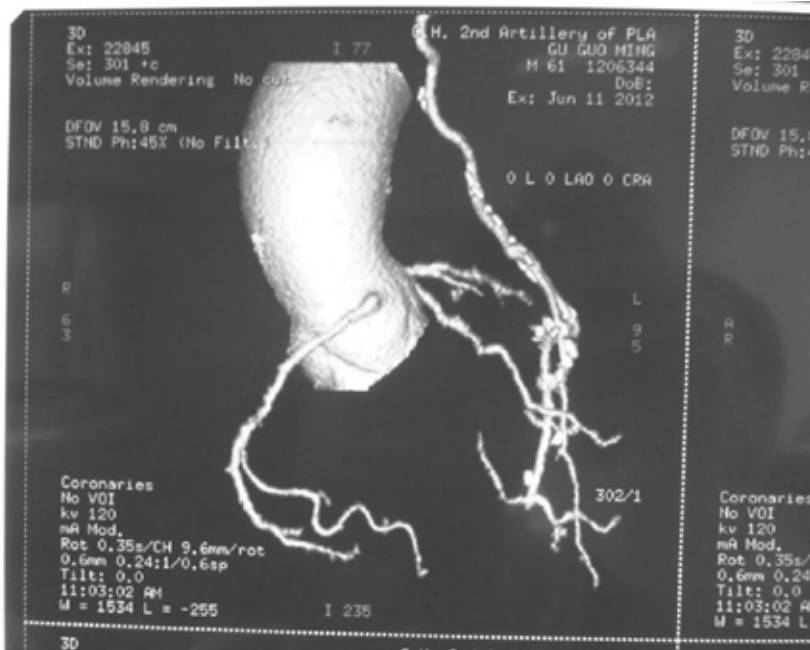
follow-up CT scanning data of CVBG.
